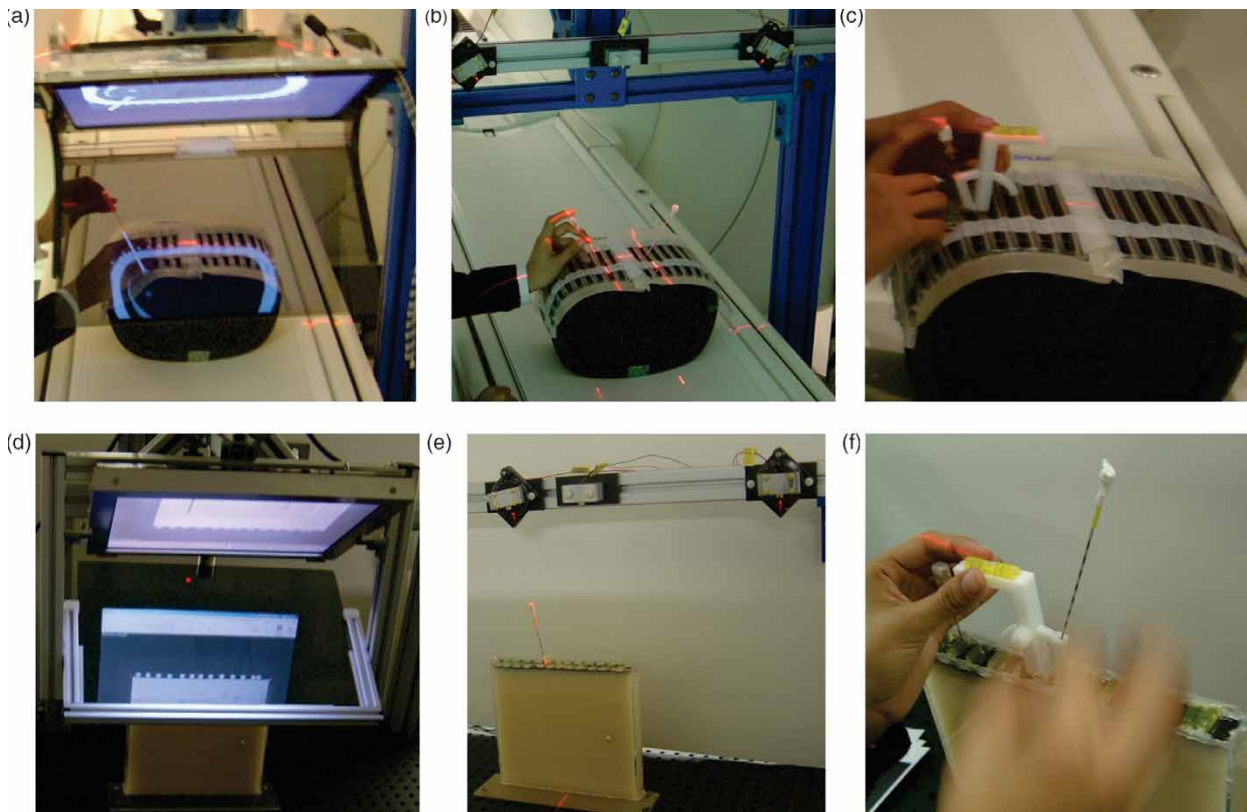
Comparison studies between the MR image overlay (a and d), a biplane laser guide (b and e), a handheld protractor guide (c and f), and the traditional freehand approach. Initial studies were performed under MR imaging (a–c) and follow-up quantitative comparisons were performed in the laboratory with a functionally equivalent system configuration (d–f). [Color version available online.]
